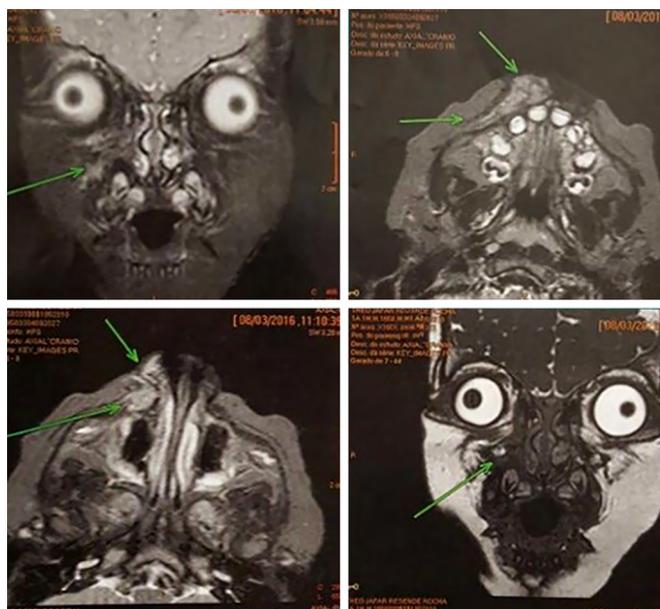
Magnetic resonance image showing an infraorbital lesion and widening of the infraorbital foramen.
